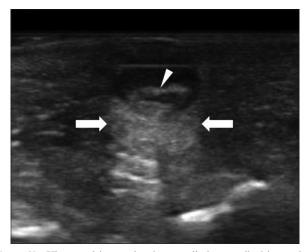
Ultrasound image showing a well-circumscribed hypoechoic masswith posterior acoustic enhancement (arrows) and hyperechoic strips (arrowheads)
